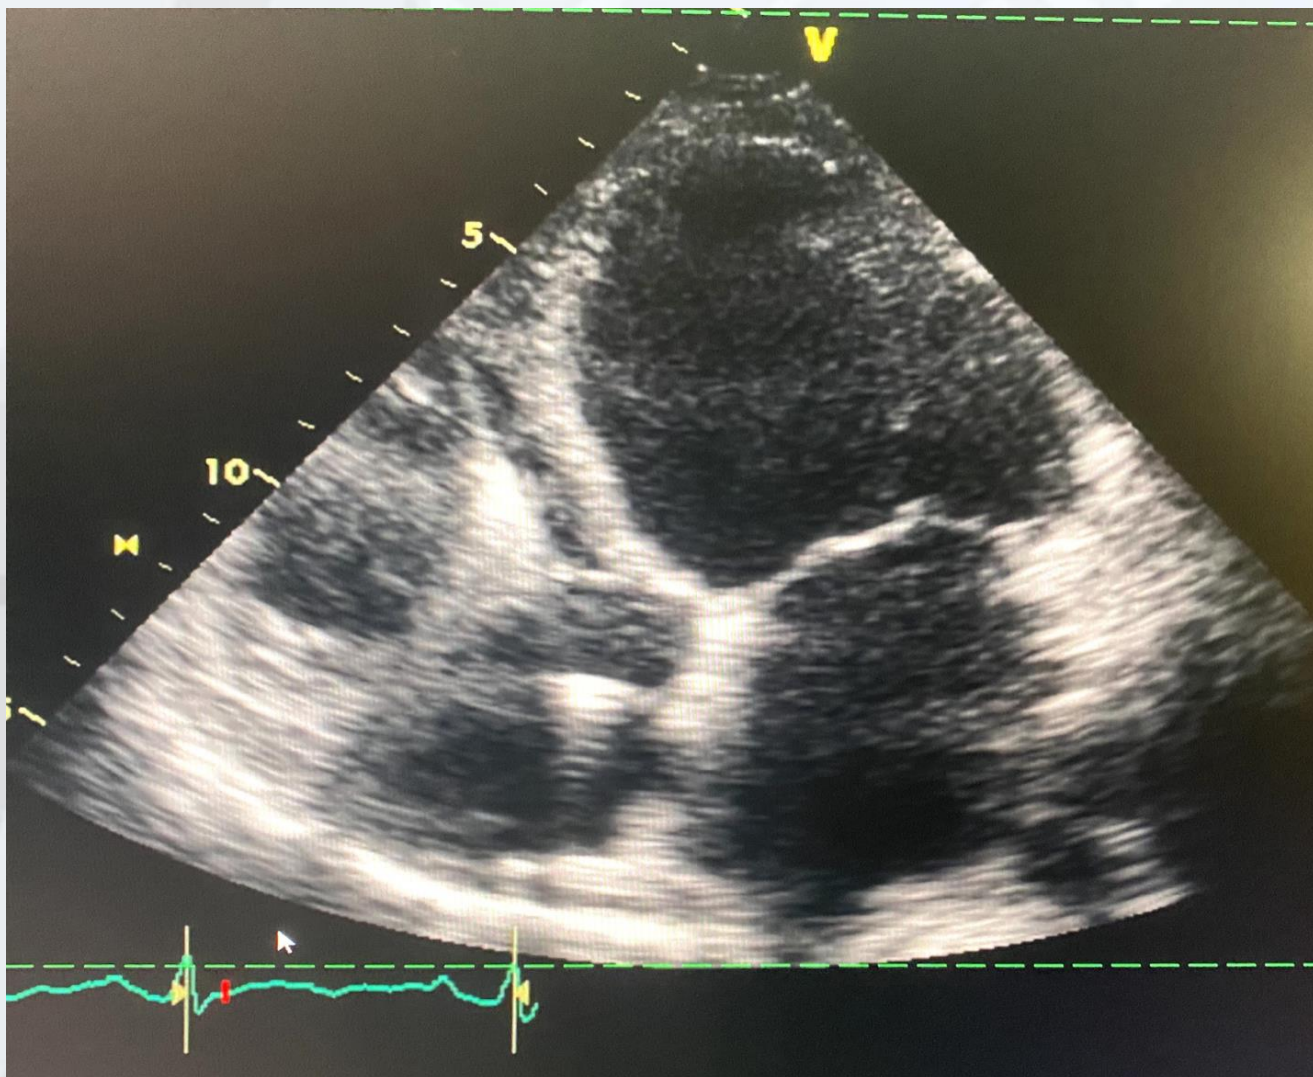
Echocardiogram during systole.
